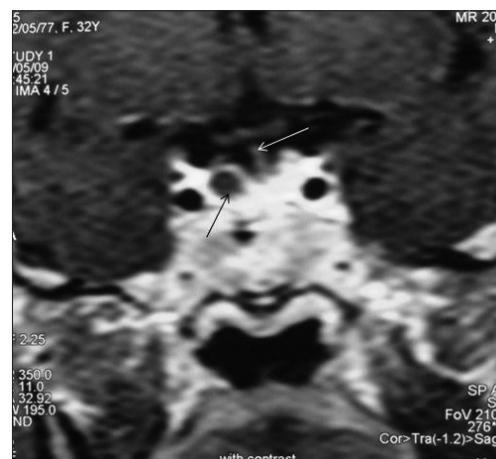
Pituitary microadenoma. High-resolution dynamic contrast-enhanced T1-weighted coronal image of brain of another patient (at 60 seconds) shows a small nonenhancing (dark) microadenoma (thin black arrow) lateralized to the right side of the pituitary gland. Note that the lesion is more conspicuous on dynamic contrast scan compared to the routine contrast scan (seen in figure 5b). The normal pituitary gland shows marked homogeneous enhancement and there is no deviation of pituitary stalk (thin white arrow) in this case
